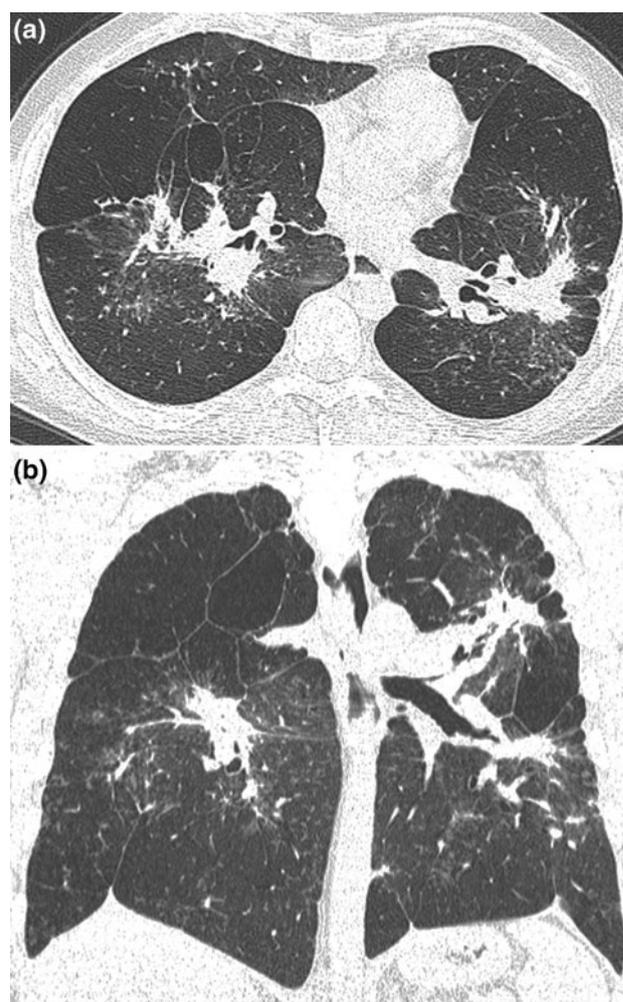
Talcosis in a 35-year-old man following chronic cocaine injection. Chest X-ray (a) shows pulmonary hyperinflation and parenchymal opacities with perihilar predominance. HRCT (b) shows hypertransparent areas corresponding to emphysema with bullous formations and irregular, conglomerated masses with architectural distortion. Small nodules also are visible
